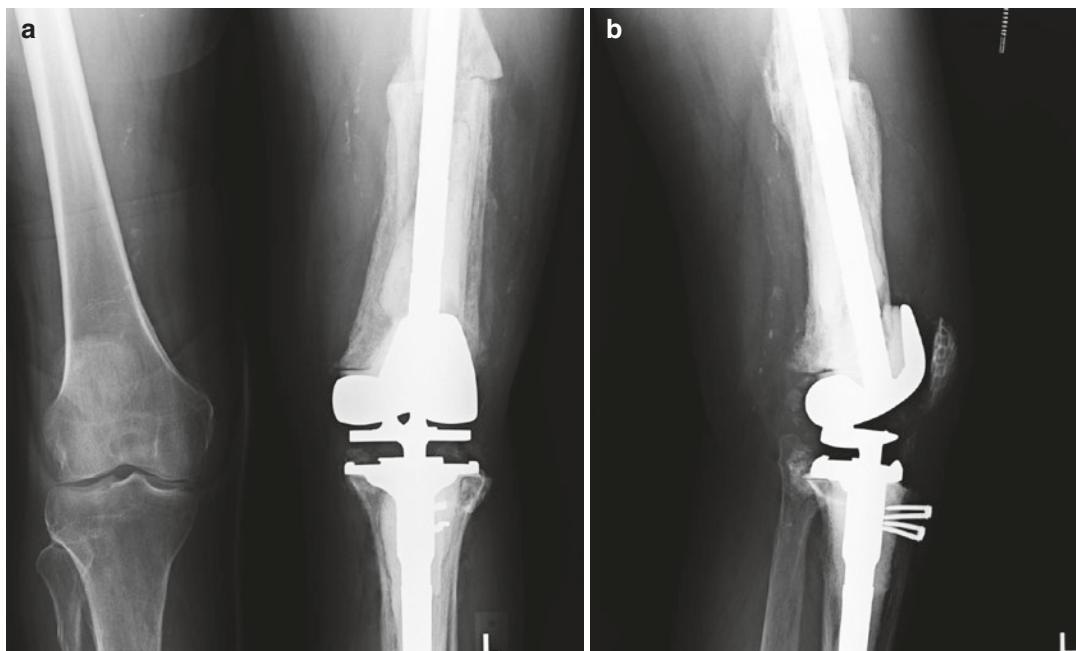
Postoperative radiographs (a, b) following the reimplantation procedure. Components are well aligned and well fixed
